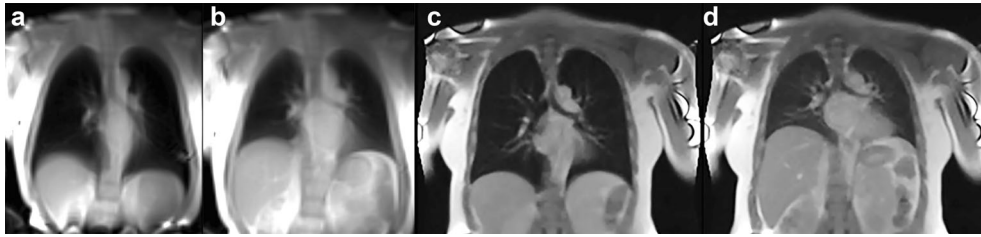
(a, b) Protocol 1 dynamic higher temporal resolution coronal MRI image slices acquired during inspiration (left) and expiration (right); in-plane resolution $4 \times 4 \text{ mm}^2$ and temporal resolution 189 msec. (c, d) Protocol 2 dynamic higher temporal resolution coronal MRI image slices acquired during inspiration (left) and expiration (right); in-plane resolution $1.8 \times 1.8 \text{ mm}^2$ and temporal resolution 208 msec.
